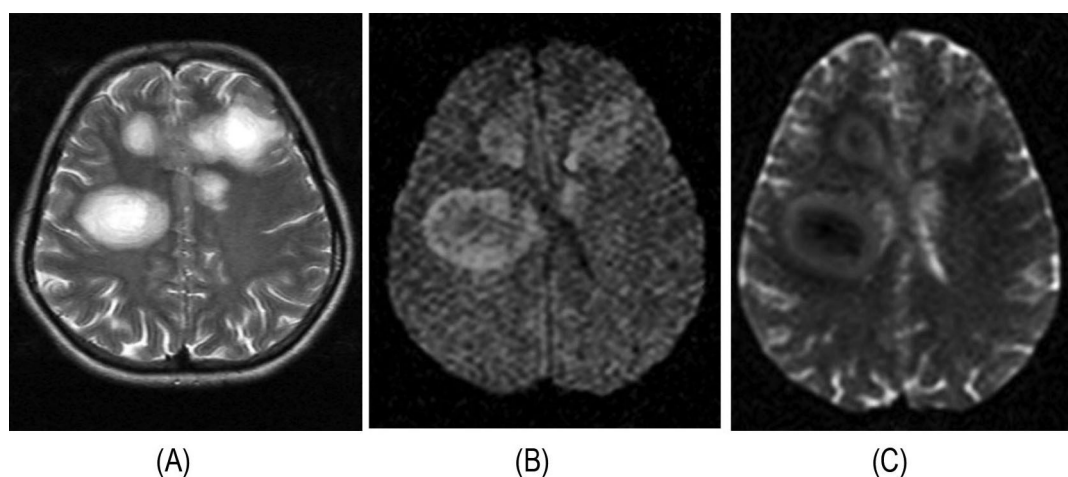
Axial T2W of acute disseminated encephalomyelitis appearing as multiple hyperintense lesions in left frontal and right fronto-parietal areas (A), bright on DWI (B) and dark on ADC (C).
